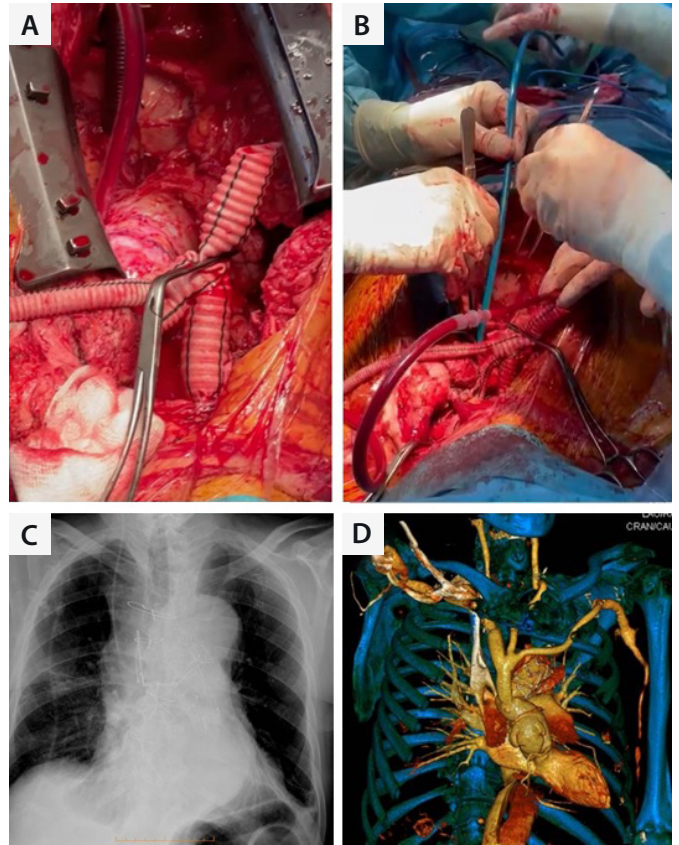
Intraoperative images of the antegrade cerebral perfusion via the custom-made graft (A) and the deployment of the thoracic endovascular aortic repair in antegrade fashion during circulatory arrest (B). Postoperative chest X-ray showing partial right hemisternum reinforcement (C) and computed tomography scan showing thoracic and epiaortic vessels reconstruction (D).
